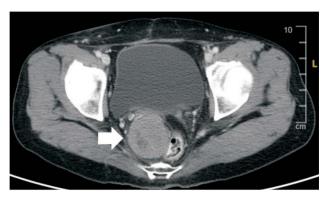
Metastatic carcinoma (Patient No. 7). The axial view of a contrast-enhanced computed tomography obtained during the venous phase showing a 5.0 cm × 4.2 cm homogeneous soft tissue mass (arrow) without contrast enhancement in the presacral space.
